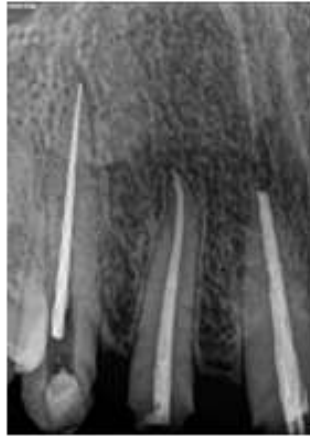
After ultrasonic troughing
